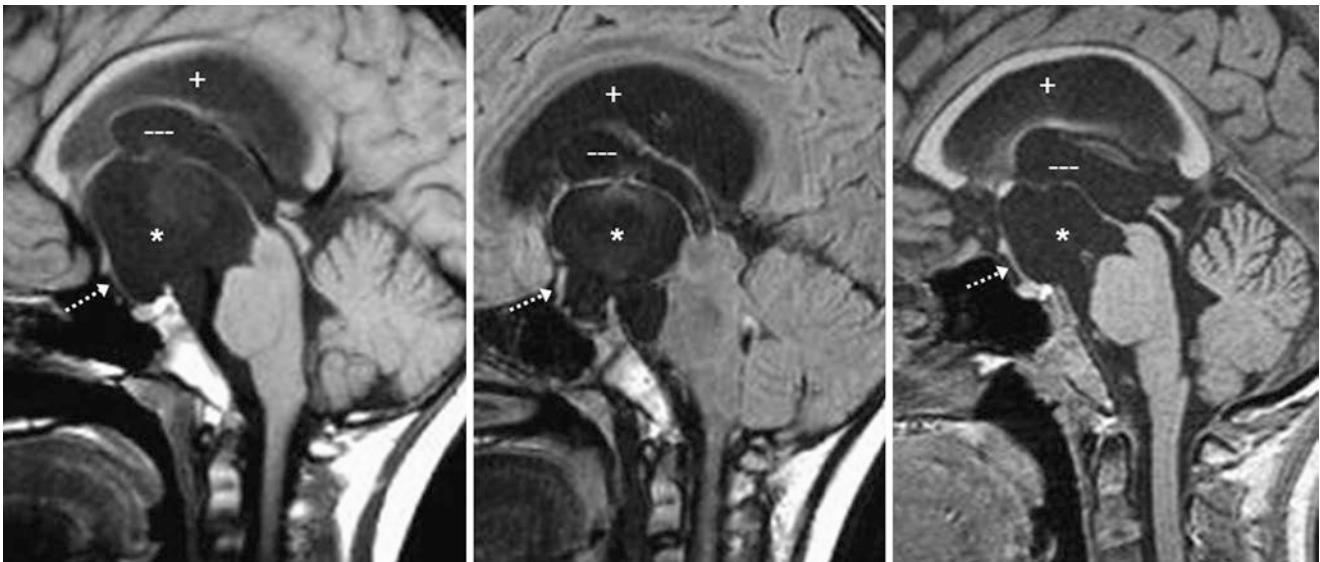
Comparison case of arachnoid cyst (suprasellar). An 11-year-old with headaches had a cyst (*) that followed CSF signal, located within the suprasellar cistern on sagittal T1WI (left) and on FLAIR (middle, to left of midline); this is the cistern and caused hydrocephalus. Note
